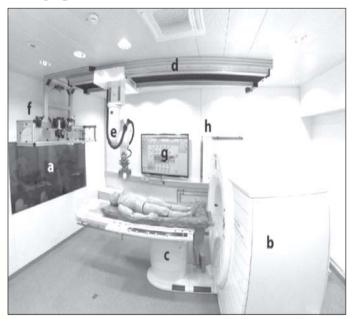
Virtobot room. A: X-Ray shielded working area; b: CT-gantry; c: CT table; d: external rail of the Virtobot; e: Virtobot mounted on external axis with lifting mechanism; f: tool stand with surface scanner, digital photo camera and biopsy module; g: monitor which is connected to the computer running the Virtobot software, h: safety light fence for device protection.
